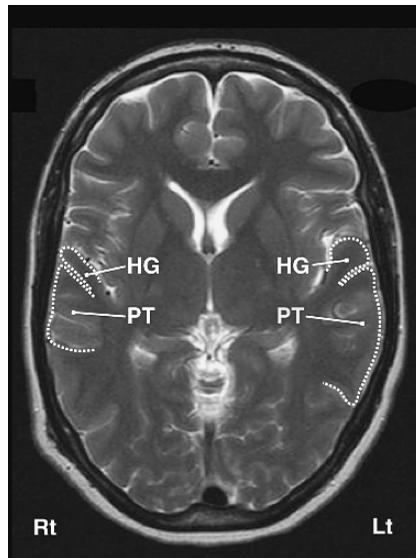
Approximation of the planum temporale (PT) in an axial MRI showing the asymmetry between right and left hemispheres. Also shown is Heschl's gyrus (HG).
